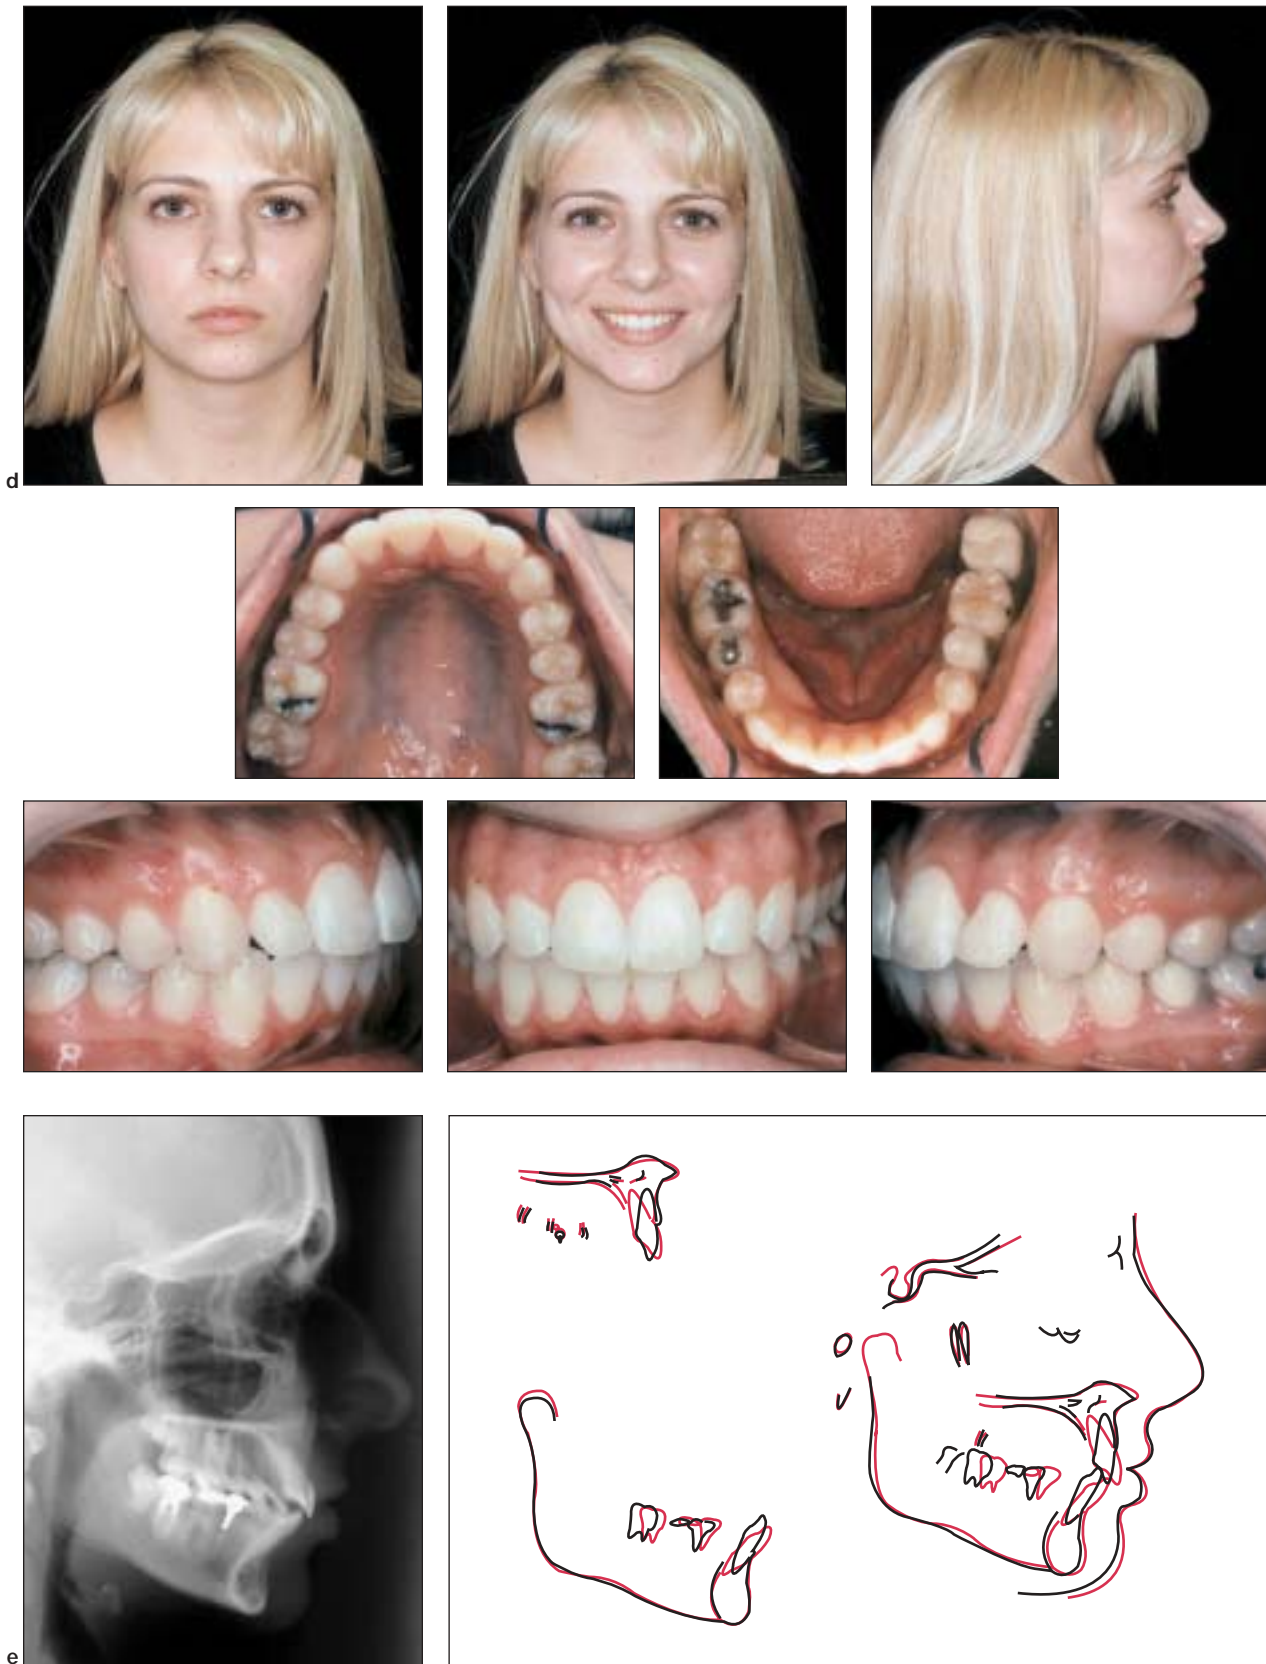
Adult patient C.M. (a) (facing page) Before treatment. (b) (facing page) With partial appliances and MARA. (c) (facing page) Upon removal of MARA. (d) After treatment. (e) Posttreatment radiograph and cephalometric tracings. Note distal position of maxillary molars.
